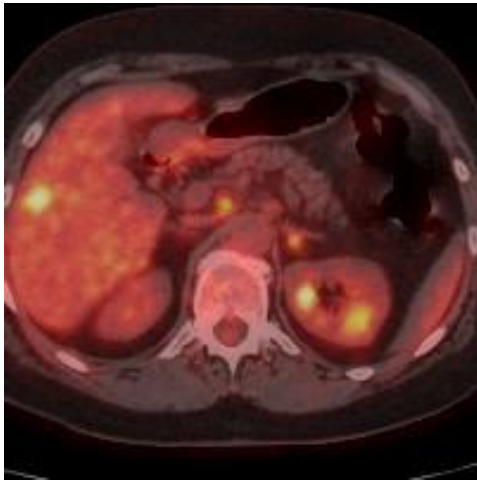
On the PET CT performed 1 month after MR, the same metastasis is shown with a high retention of the intravenously applied radioisotope FDG 18, with an SUV max of 6.7
